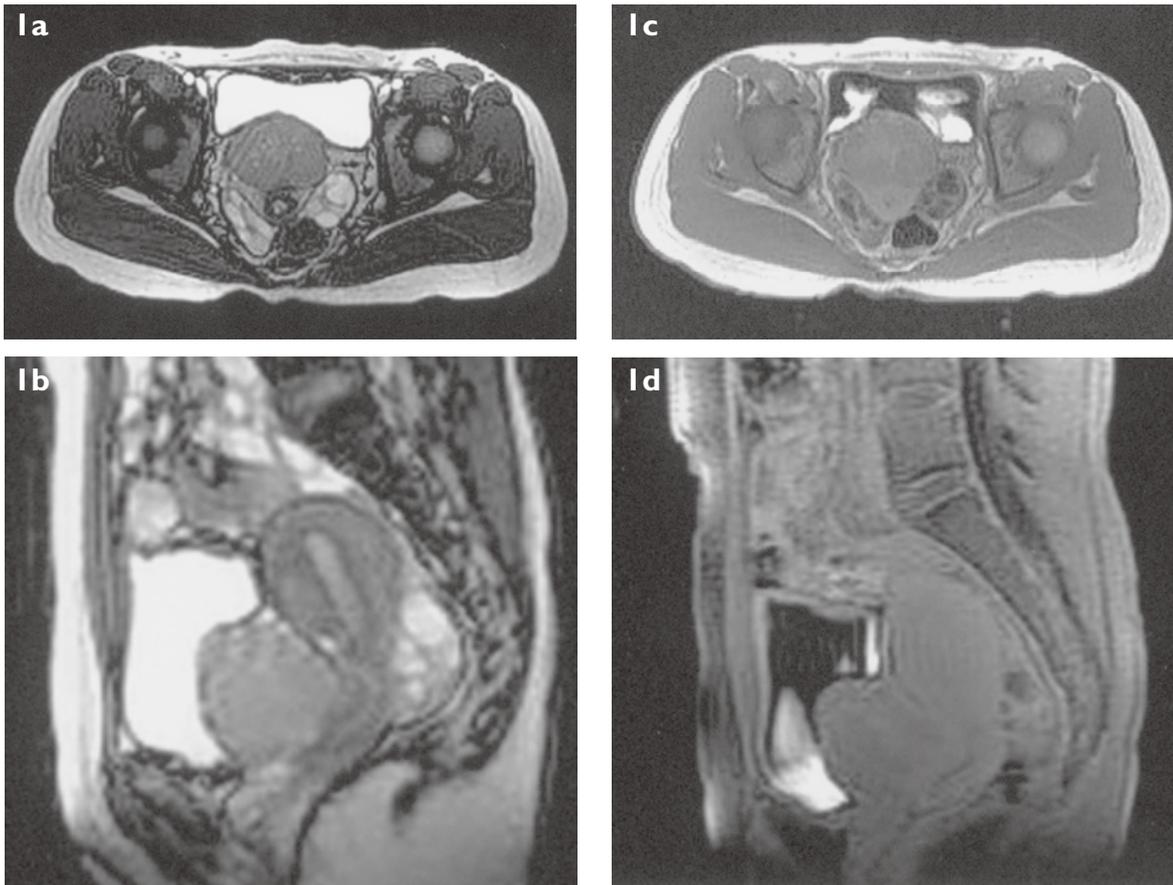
(a) Axial and (b) sagittal T2-W MR images show a well-circumscribed isointense mass located between the bladder anteriorly and the cervix posteriorly. Enhanced (c) axial and (d) sagittal T1-W MR images show minimal enhancement of the mass.
